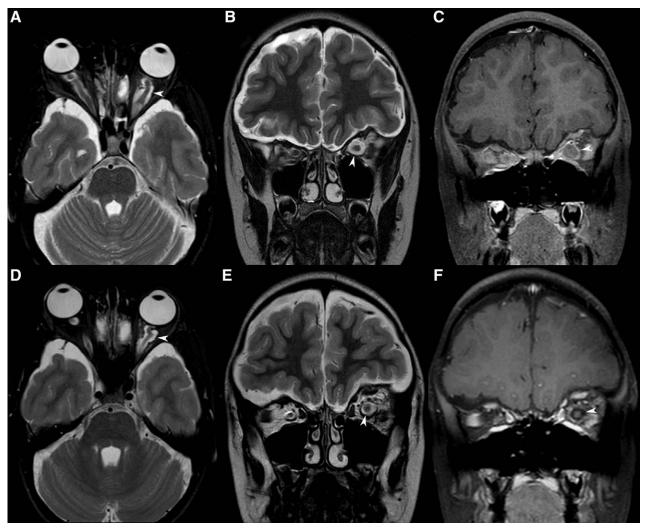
A and D, Fat-suppressed axial T2-weighted MRI images show tortuous, Z-shaped left optic nerve with enlarged sheath (*arrowheads*). B and E, Coronal T2-weighted images confirm marked enlargement of the left optic nerve sheath (*arrowheads*), showing slightly hypointense signal about cerebrospinal fluid. Also notice dilated intracranial subarachnoid spaces with diffuse scalloping of the inner table of the skull. The brain parenchyma is not affected. C and F, Contrast-enhanced, fat-suppressed coronal T1-weighted images show enhancement of the left optic nerve sheath (*arrowheads*); centrally, the optic nerve fibers do not enhance.
